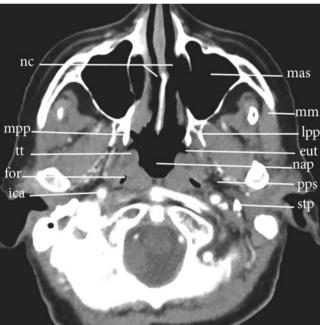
Radiographic image at level of nasopharynx. Abbreviations are located in Appendix B at end of chapter
